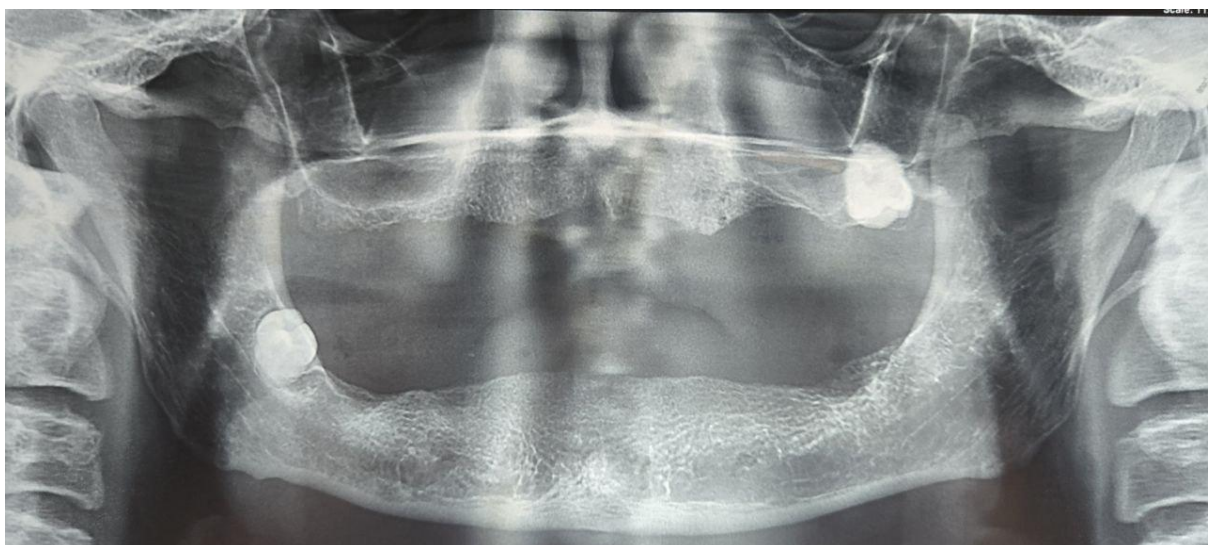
Pre-treatment diagnostic orthopantomogram (OPG).
